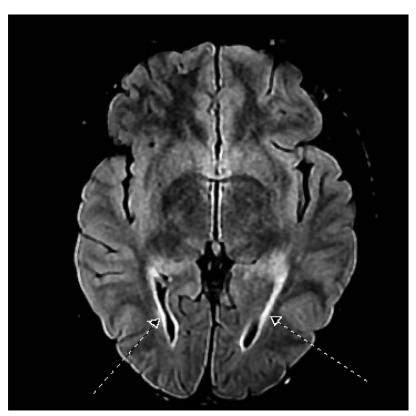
Diffuse relatively symmetric ill-defined T2 fluid-attenuated inversion recovery (FLAIR) hyperintensity along the ependymal surface of the lateral ventricles.
